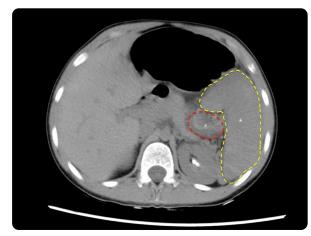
Simple phase CT, the spleen is observed with the usual location (*), hypodense in relation to the liver, linear hyperdense images compatible with thrombosed vascular structures in the splenic hilum (X).
